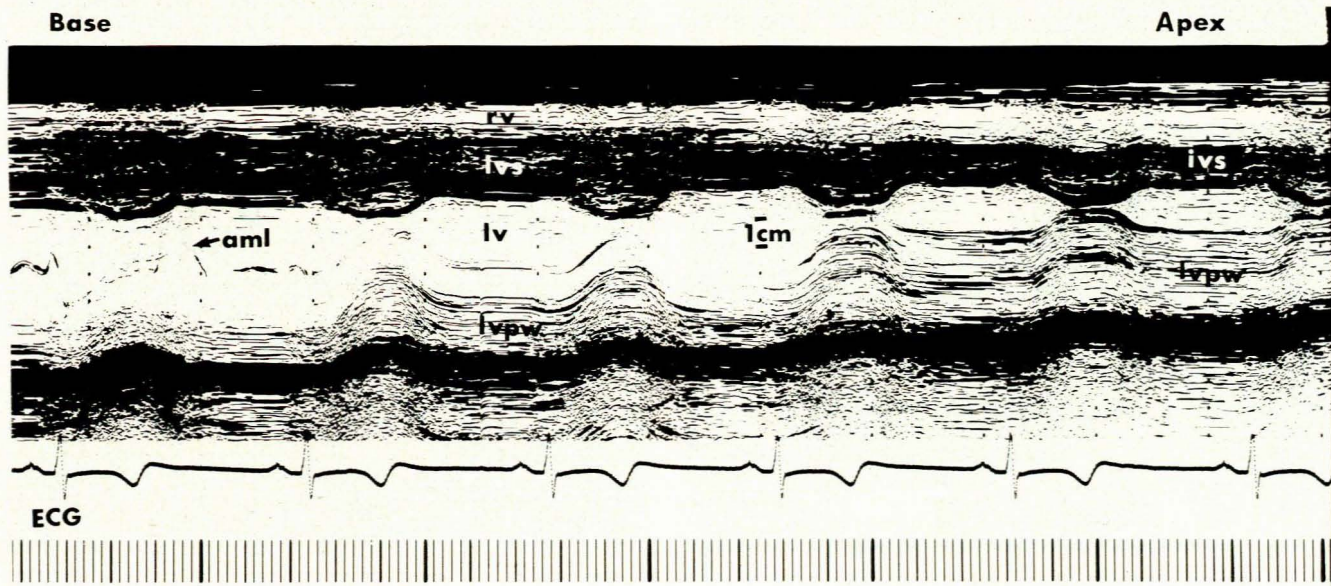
M-mode echocardiogram demonstrating reduction in the left ventricular cavity towards the apex (especially during systole) mainly due to gross hypertrophy of the posterior wall (rv = right ventricle; lv = left ventricle; ivs = interventricular septum; lvpw = left ventricular posterior wall; aml = anterior mitral leaflet).
